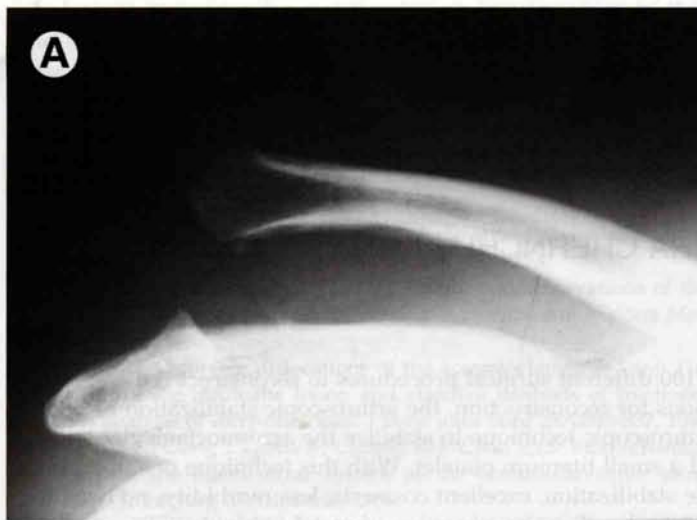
Preoperative anteroposterior (A) and transscapular (B) radiographs of a patient with acromioclavicular joint dislocation.
